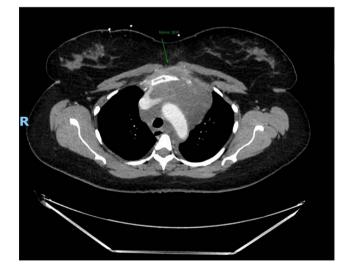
CT scan demonstrating anterior invasion of mediastinum.
